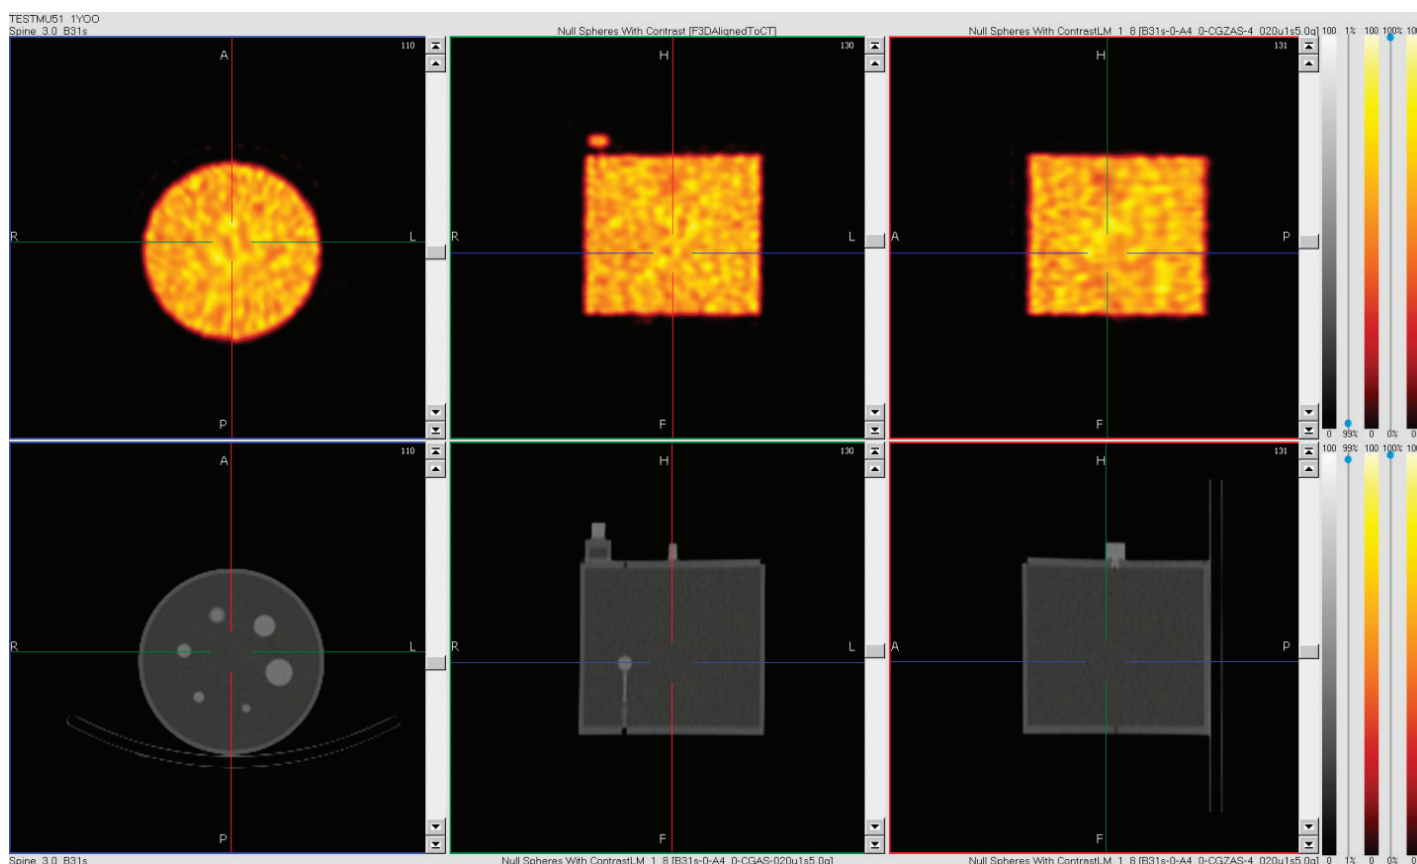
xSPECT Bone. Use of CT data to generate an attenuation map, as well as a zone map (display from research workstation).
